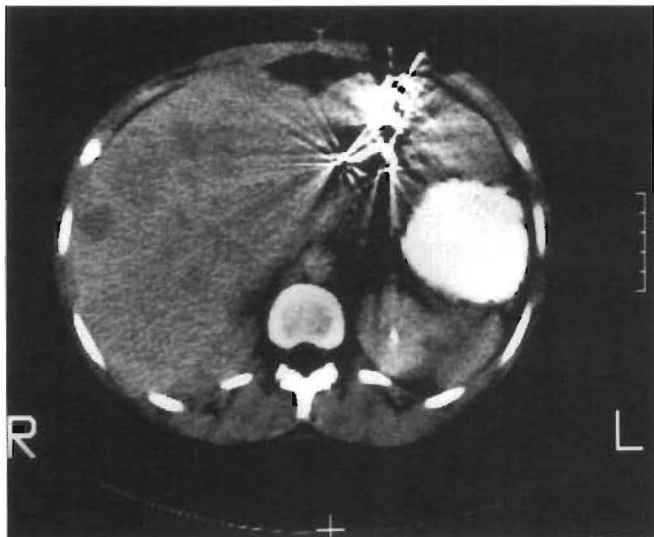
Pre OLTx CT scan, case no. 3. Surgical clips (related to previous left and right segmental resection) can be noted in the liver. Inhomogeneity with multiple low density areas can be noted throughout all lobes of the liver
